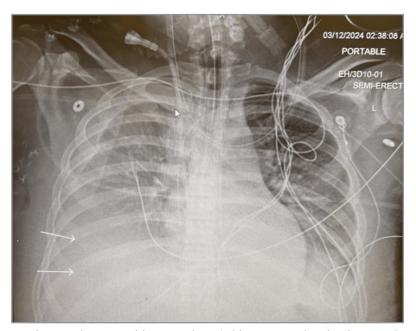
Portable chest X-ray in a semi erect position, AP view; (white arrows; showing increased opacity and blunting of R costophrenic angles), depicting moderate pleural effusion.
